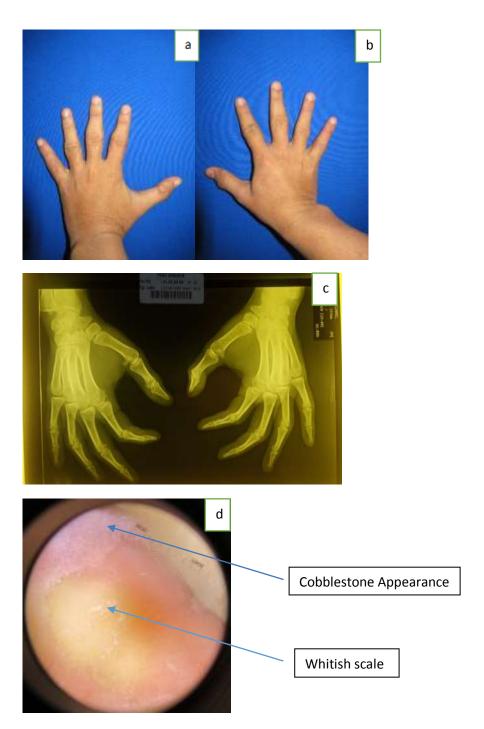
(a)-(b) lesion on lateral aspect of both hands (c) Plain radiography shows no joint and bone abnormality (d)dermoscopy shows whitish scale and cobblestone appeareance
